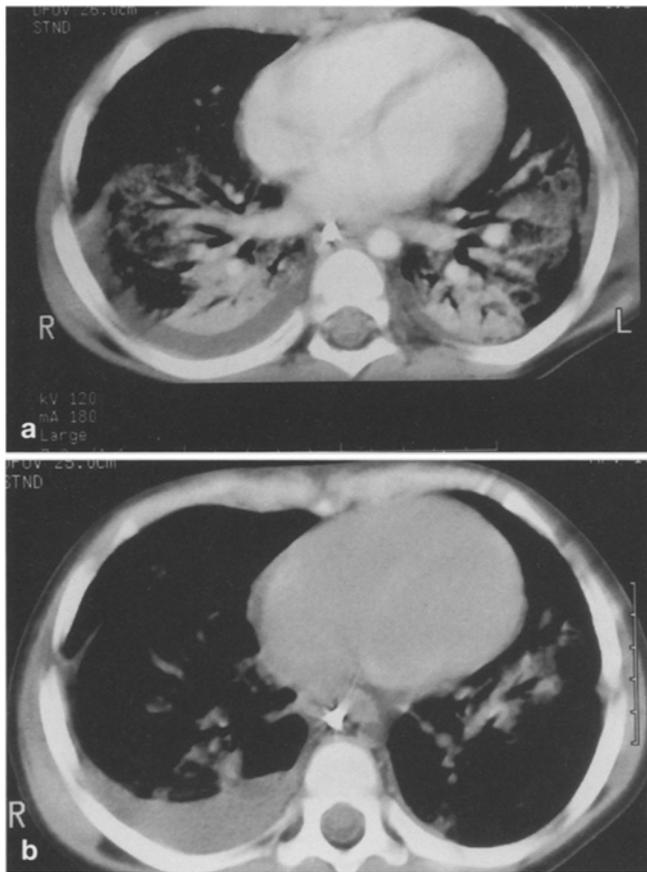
Computed tomography of the lungs in a patient with acute respiratory distress syndrome of the adult (ARDS) caused by viral pneumonia before a and after b surfactant replacement therapy. Scan taken between carina and diaphragm level
